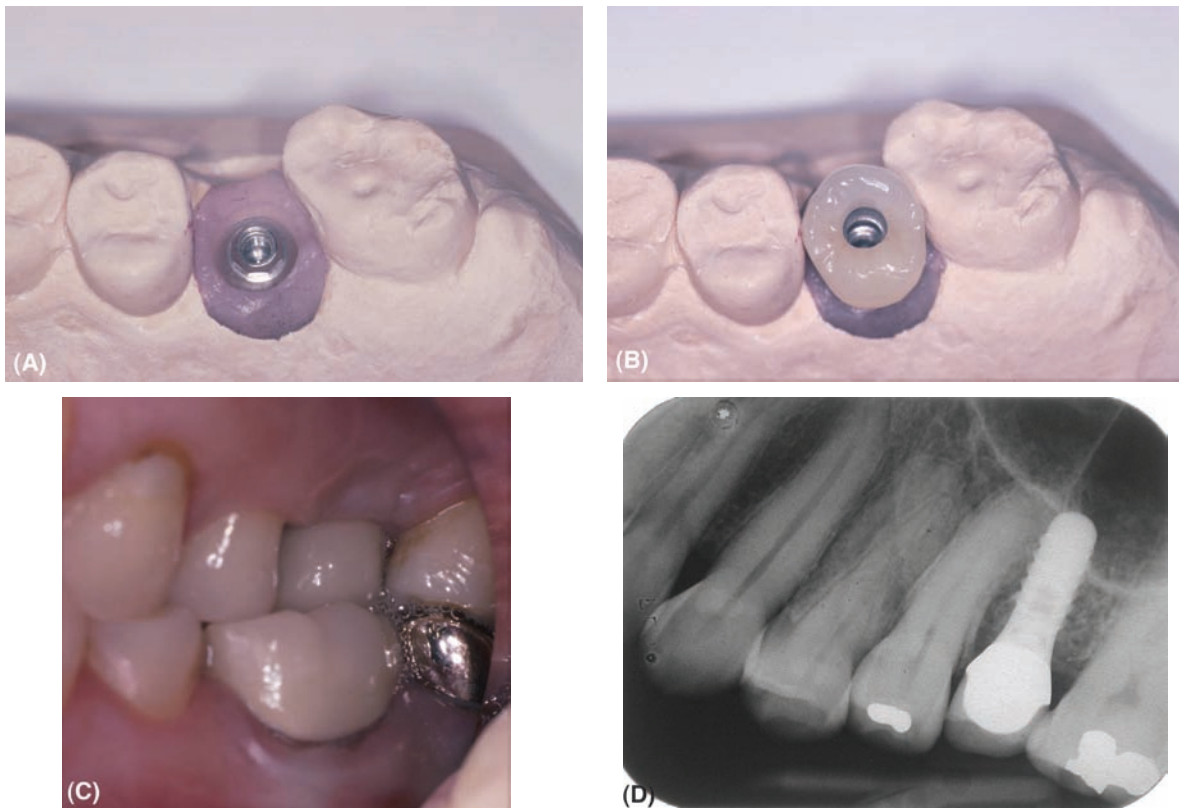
A single Straumann implant placed for a missing upper second premolar tooth: (A) The working cast with replica of the implant. (B) Completed crown—the screw access hole is centrally placed. (C) Buccal view of the crown in position—the upper teeth are in cross bite with the lower teeth. (D) Periapical radiograph of the completed restoration.
